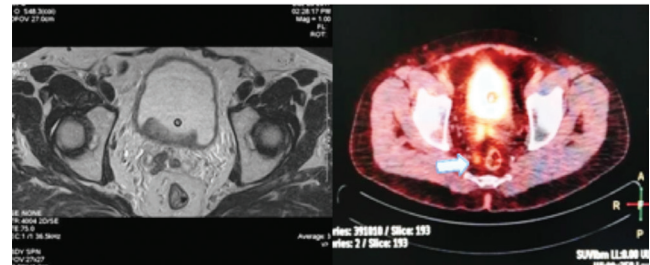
The comparison of PSMA image and MRI image
